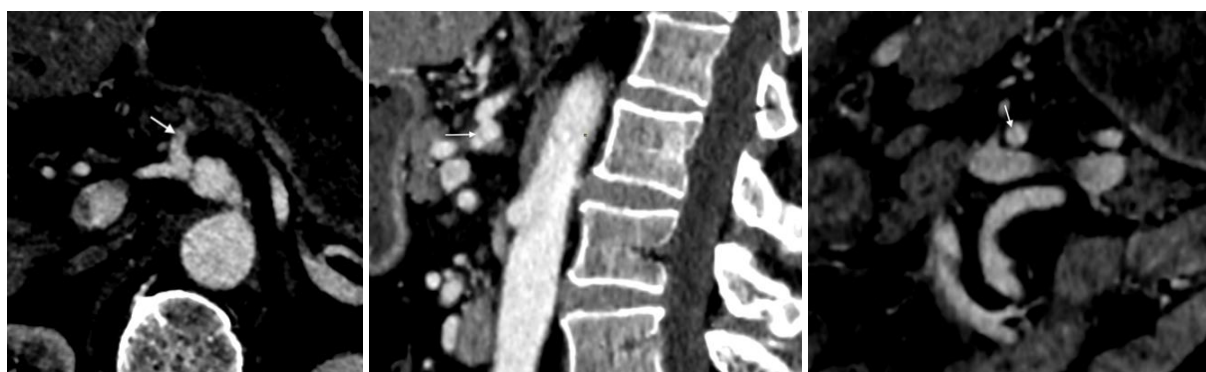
Axial contrast-enhanced abdominal CT during the arterial phase demonstrating: a. aneurysmal dilatation of the celiac trunk (asterisk)
